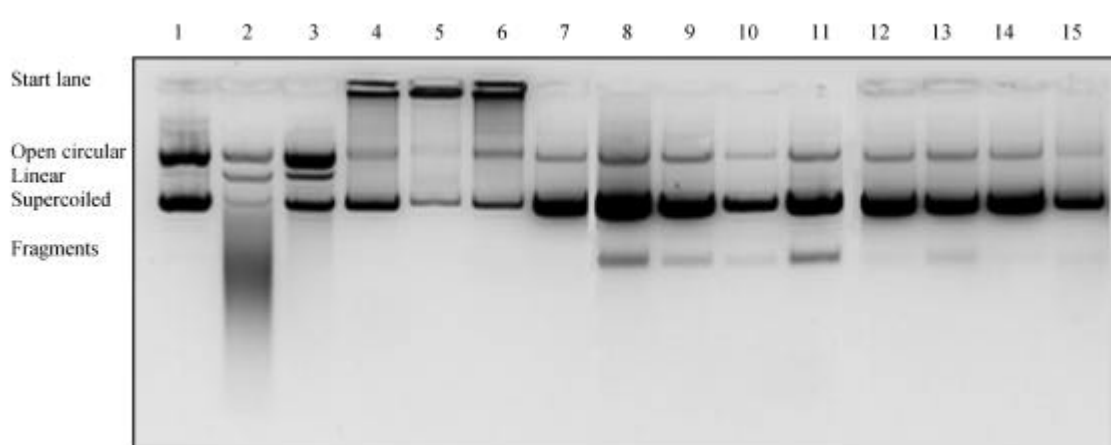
Agarose gel of non-nebulized and nebulized DNA and PEI/DNA: lane 1-3 showing DNA: non-nebulized (1), air-jet nebulized (2), ultrasonic nebulized (3); lane 4-7 showing non-nebulized polyplexes: BPEI (4), linPEI (5), PEGPEI (6), bioPEI (7); lane 8-11 showing air-jet nebulized polyplexes: BPEI (8), linPEI (9), PEGPEI (10), bioPEI (11); lane 12-15 showing ultrasonic nebulized polyplexes: BPEI (12), linPEI (13), PEGPEI (14), bioPEI (15).
